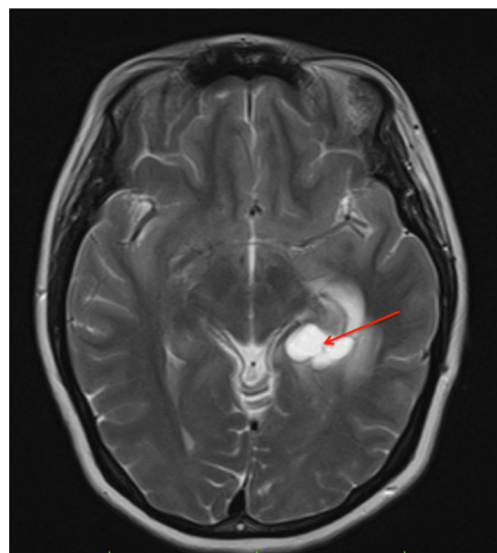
MRI scan of the patients brain with arrow pointing to cystic lesion compression atrium of lateral ventricles (horizontal section).
